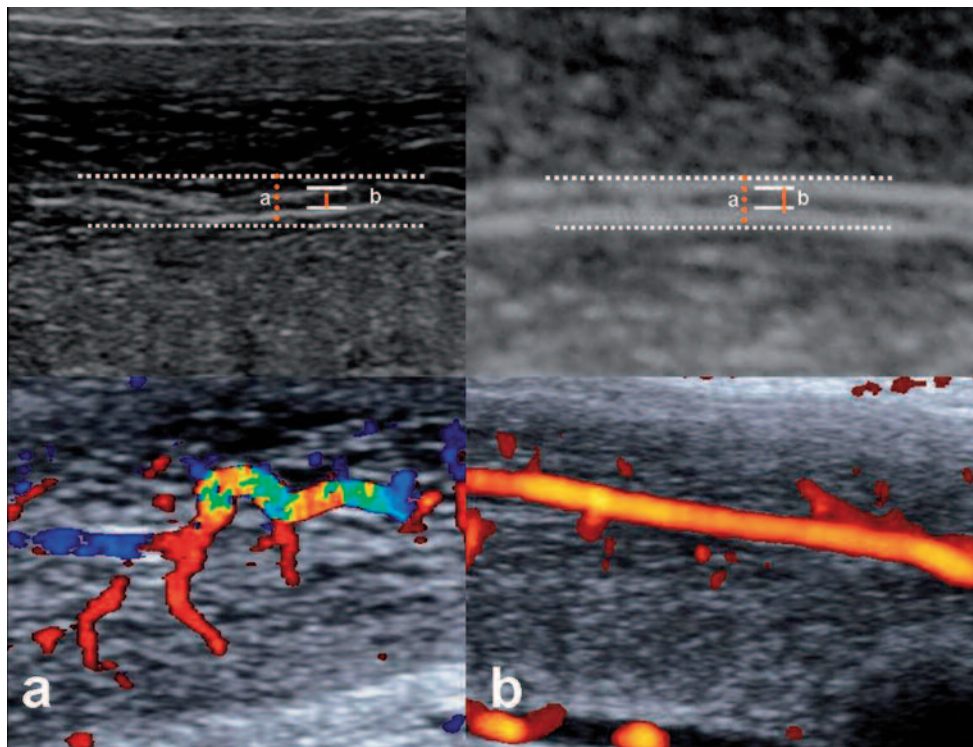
Color Doppler images of cavernous arteries in two different cases. Color Doppler image of an undulating (*a*) and power Doppler image of a flattened (*b*) trace of the related arteries. CA-OI = 3.1 of first case in a represents severe tortuosity, and CAOI = 2.2 for the other image shows less tortuous course of the examined cavernous arteries. And also it has been seen that the color aliasing in (*a*) which was related with the turbulence due to the zigzag flow. Whereas the flow in (*b*) shows laminary pattern.
